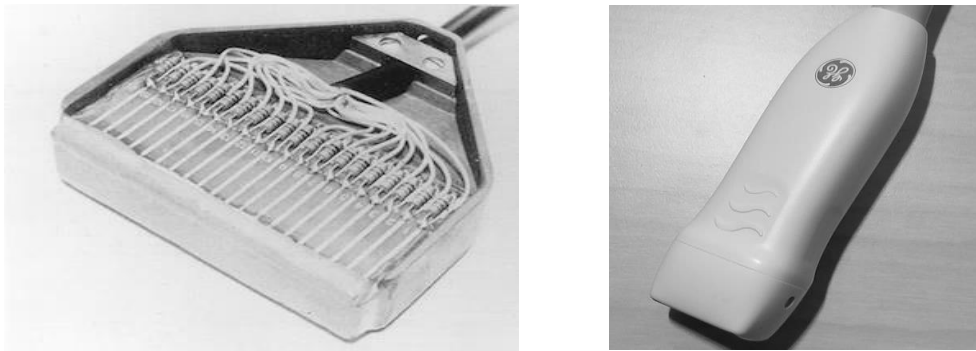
A multi-element transducer that provides an electronic linear scan to represent the first real-time, 2D, echocardiography (Left image, with permission: Circulation; 1996; 93 (7): 1321-1327) and a modern sector scanner transducer (Right).
